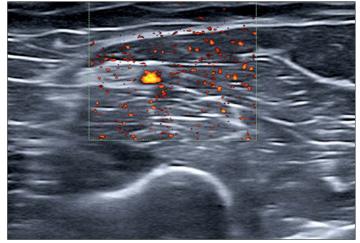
The color Doppler image shows the close relationship of the nerve trunk and artery.
